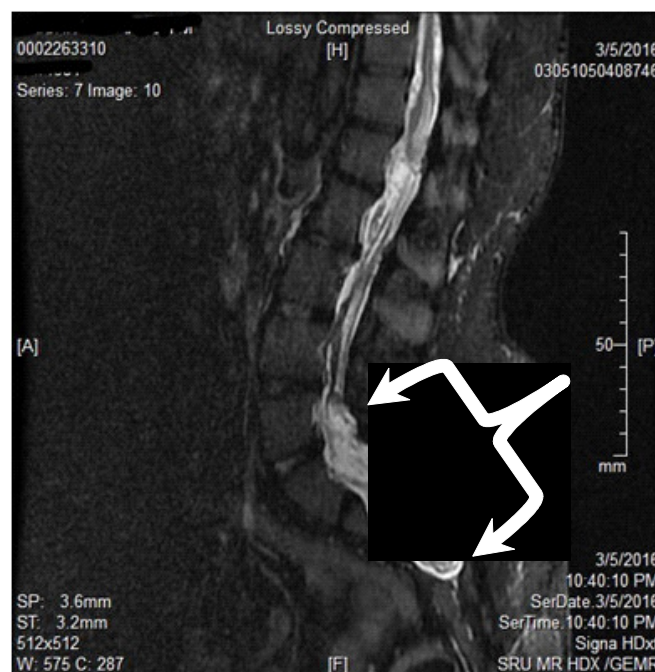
MRI revealing intradural lesion at level of S4 to L2
